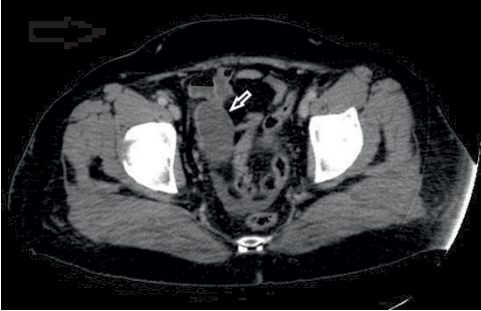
Axial CT image shows a dilated appendix which is coming down to the pelvis.
